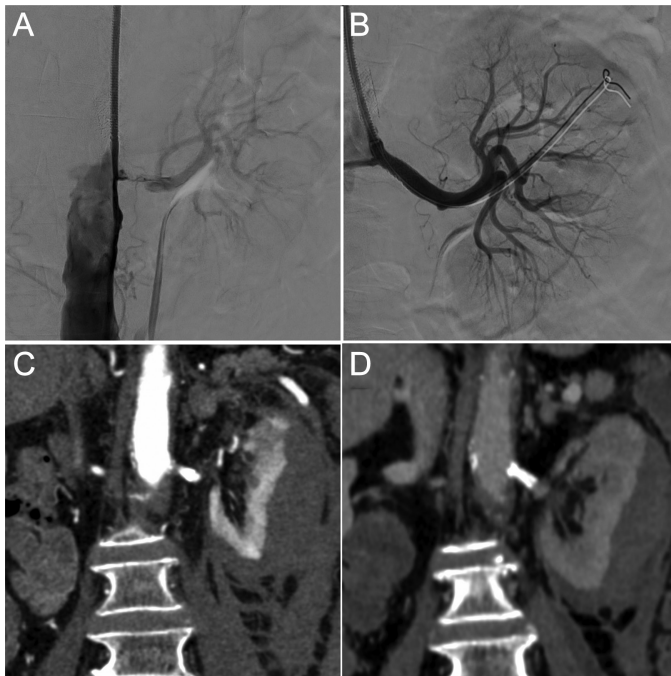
(A) Digital subtraction angiographic image of left renal artery reached in an antegrade manner showed the presence of ostial narrowing. (B) Digital subtraction angiographic image of the left renal artery after transluminal angioplasty revealed normal renal artery caliber. The branches of the left renal artery and contrast enhancement of the parenchyma were normal. (C) Computed tomography of the patient was taken 7 hours after the procedure due to a complaint of flank pain. Computed tomography showed left renal subcapsular hematoma compressing the renal parenchyma along the long axis on the coronal view. (D) A computed tomography image obtained 10 days after the procedure showed minimal regression of the left renal subcapsular hematoma.
